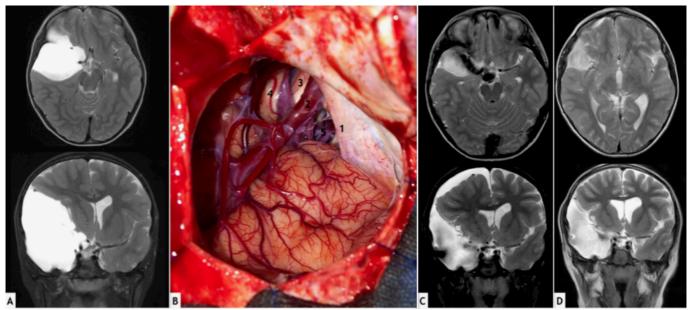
Pre operative MRI image and surgical picture: A - Axial and coronal views of a large Galassi type III cyst; B - Surgical picture after right middle fossa arachnoid cyst fenestration through craniotomy and microsurgery (1 - Tentorium; 2 - Internal carotid artery; 3 - Optic nerve; 4 - Olfatory nerve; 5 - Large opening of the Liliquist membrane exposing the infra tentorial contents as both oculomotor nerves and basilar artery); C - One month post operative MRI showing good communication of the cyst with the basal cisterns, and subdural effusion on the coronal view; D - Six month post operative MRI showing spontaneous resolution of the subdural effusion.
